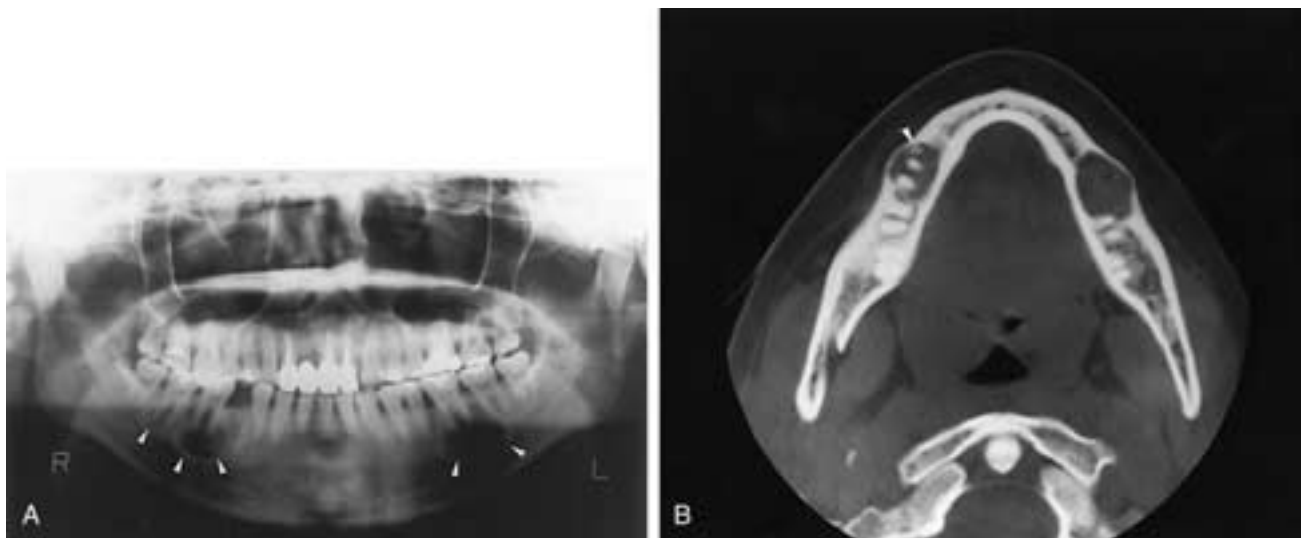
Cemental dysplasia in the mandible. A, Pantomogram shows multiple periapical radiolucent lesions with radiopaque areas in the mandible (arrowheads). This appearance may be indistinguishable from that of radicular cyst. B, Axial CT shows one expansile low-density lesion with tiny calcifications (arrowhead) and another expansile lesion without calcification. These are the early stages of cemental dysplasia.
